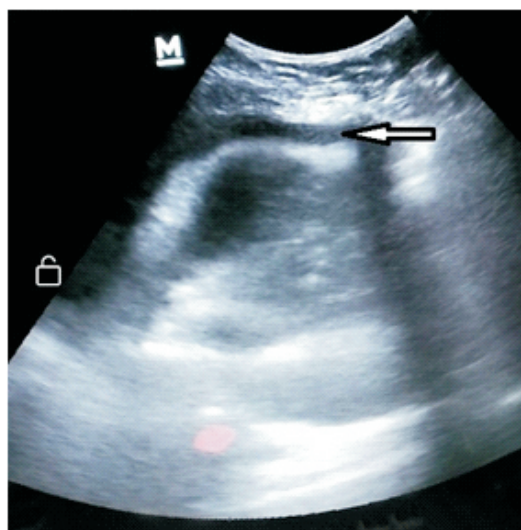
Bedside ultrasound scan showing evidence of a pericardial effusion
